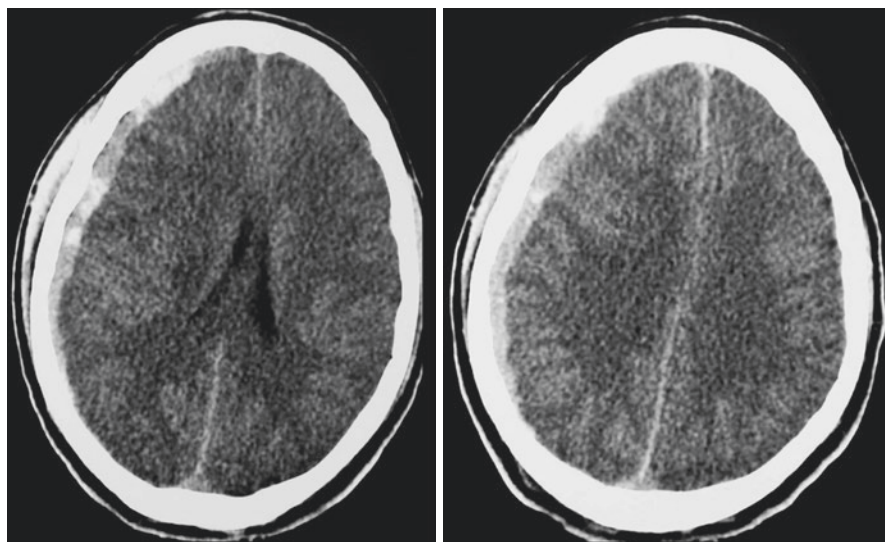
Axial CT-scan revealing a post-traumatic acute subdural hematoma on the right side
